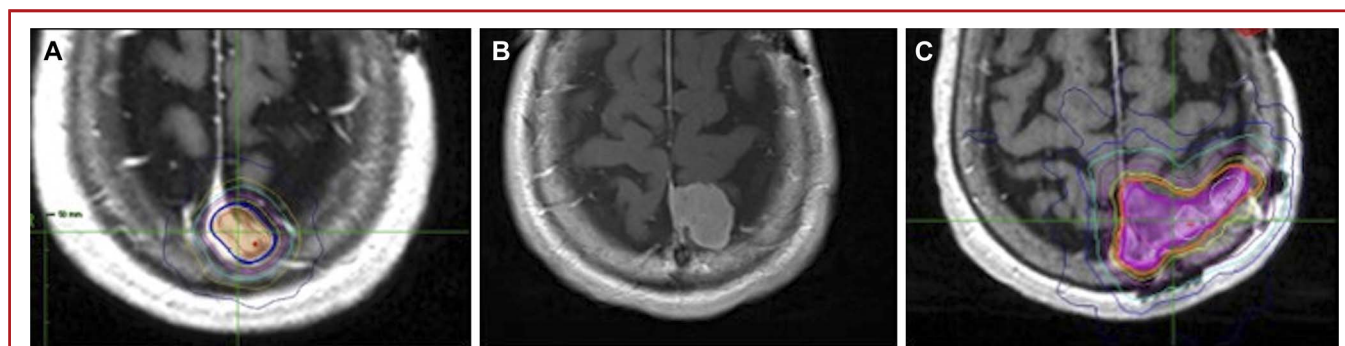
A, Initial SRS volume; B, interval MRI showing progression; C, and postresection repeat SRS target volume in a single patient. SRS, stereotactic radiosurgery.
